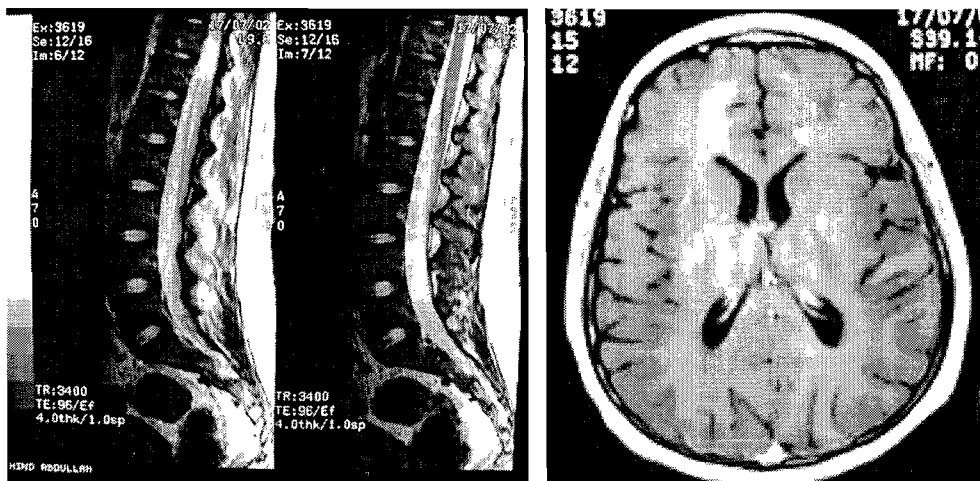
MRI of the lumbo-sacral spine (A) and the brain (B). No lesions are evident.
